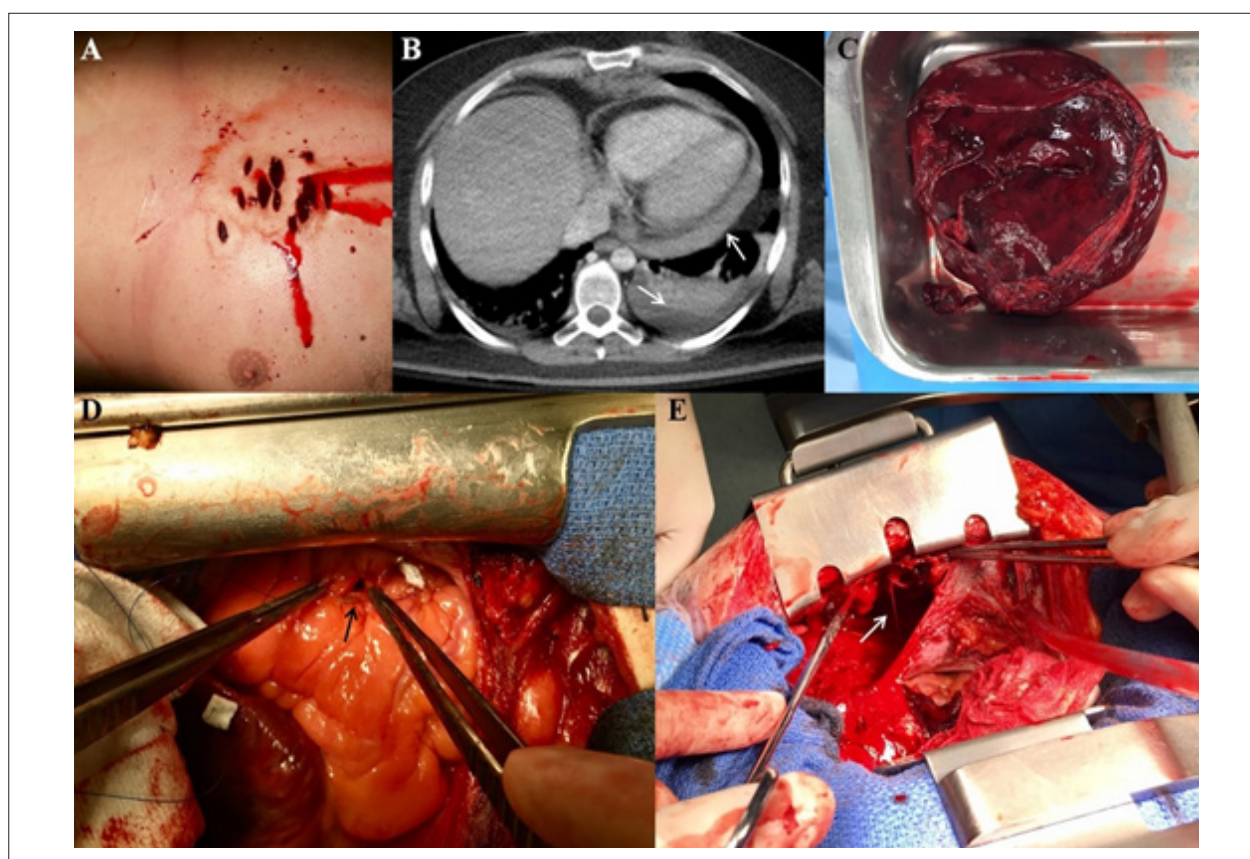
Panel A: Eleven knife-wounds localized in the left-anterior chest wall. Panel B: Axial computed tomography showed severe pericardial and left pleural effusion (white arrows). Panel C: The clot drained from the pericardial cavity. Panel D: Right ventricular perforation repaired using a monofilament suture (black arrow). Panel E: Complete mammary artery transection bleeding into left pleural cavity (white arrow).
